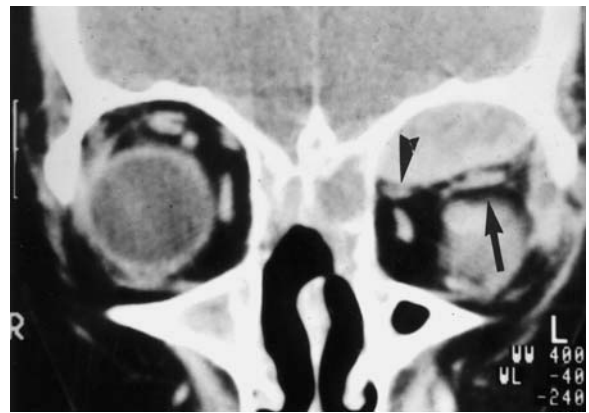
A 35-year-old woman with acute exophthalmos developing a few hours after a nasal sinus operation. Diagnosis: subperiosteal hematoma. Coronal CT: sharply defined, biconvex, homogeneous, hyperdense, space-occupying lesion at the orbital roof with caudal dislocation and flattening of the superior rectus (*arrow*) and superior oblique (*arrowhead*) muscle, completely shaded ethmoidal cells. (With permission of MÜLLER-FORELL and LIEB 1995b)
